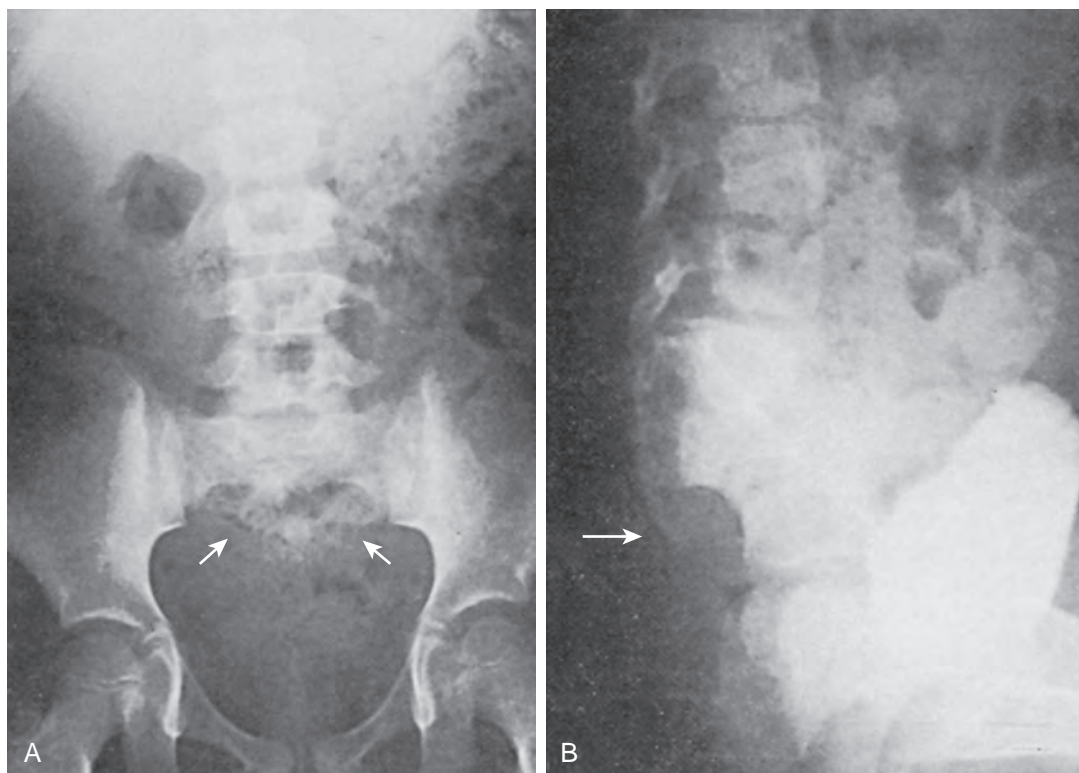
The diagnosis of partial or complete sacral agenesis (arrows) is easily confirmed on an anteroposterior (A) or lateral (B) radiograph of the spine if bowel gas obscures the sacral area. (From Bauer SB. Early evaluation and management of children with spina bifida. In: King LR, editor. Urologic surgery in neonates and young infants. Philadelphia: Saunders; 1988. p. 283–310.)
